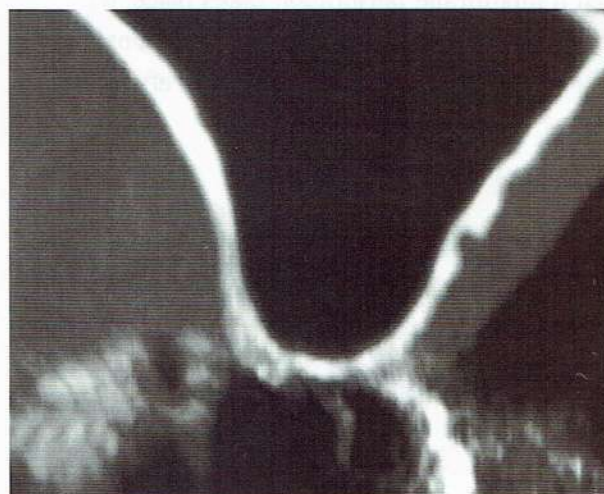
Preoperative CT image of left first molar
